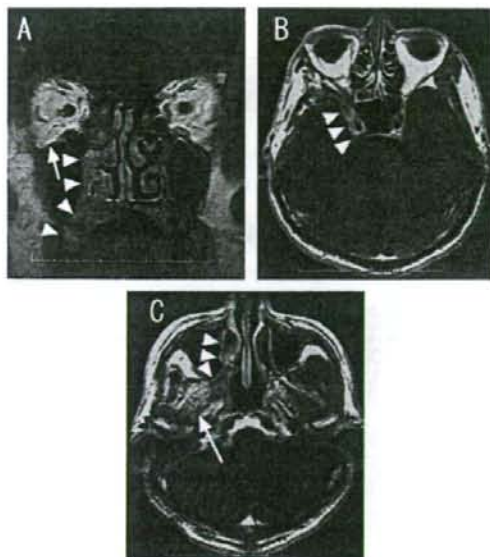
MR imaging performed 4 months after the MR and SPECT studies showed marked thickening with contrast enhancement from the medial portion of the right maxillary sinus to the right palate (A and C, arrowheads). Disease progression was also noted in the maxillary division of the trigeminal nerve along the right foramen rotundum (B, arrowheads). By contrast, there was no evidence of disease progression in the right infraorbital nerve (A, arrow) and around the right pterygoid muscle (C, arrow). MR imaging is of great value in the evaluation of head and neck cancers,⁶ although its possible limitation of post-therapeutic evaluation suggests the need for nuclear imaging such as positron emission tomography (PET) and SPECT.^{7,8}
